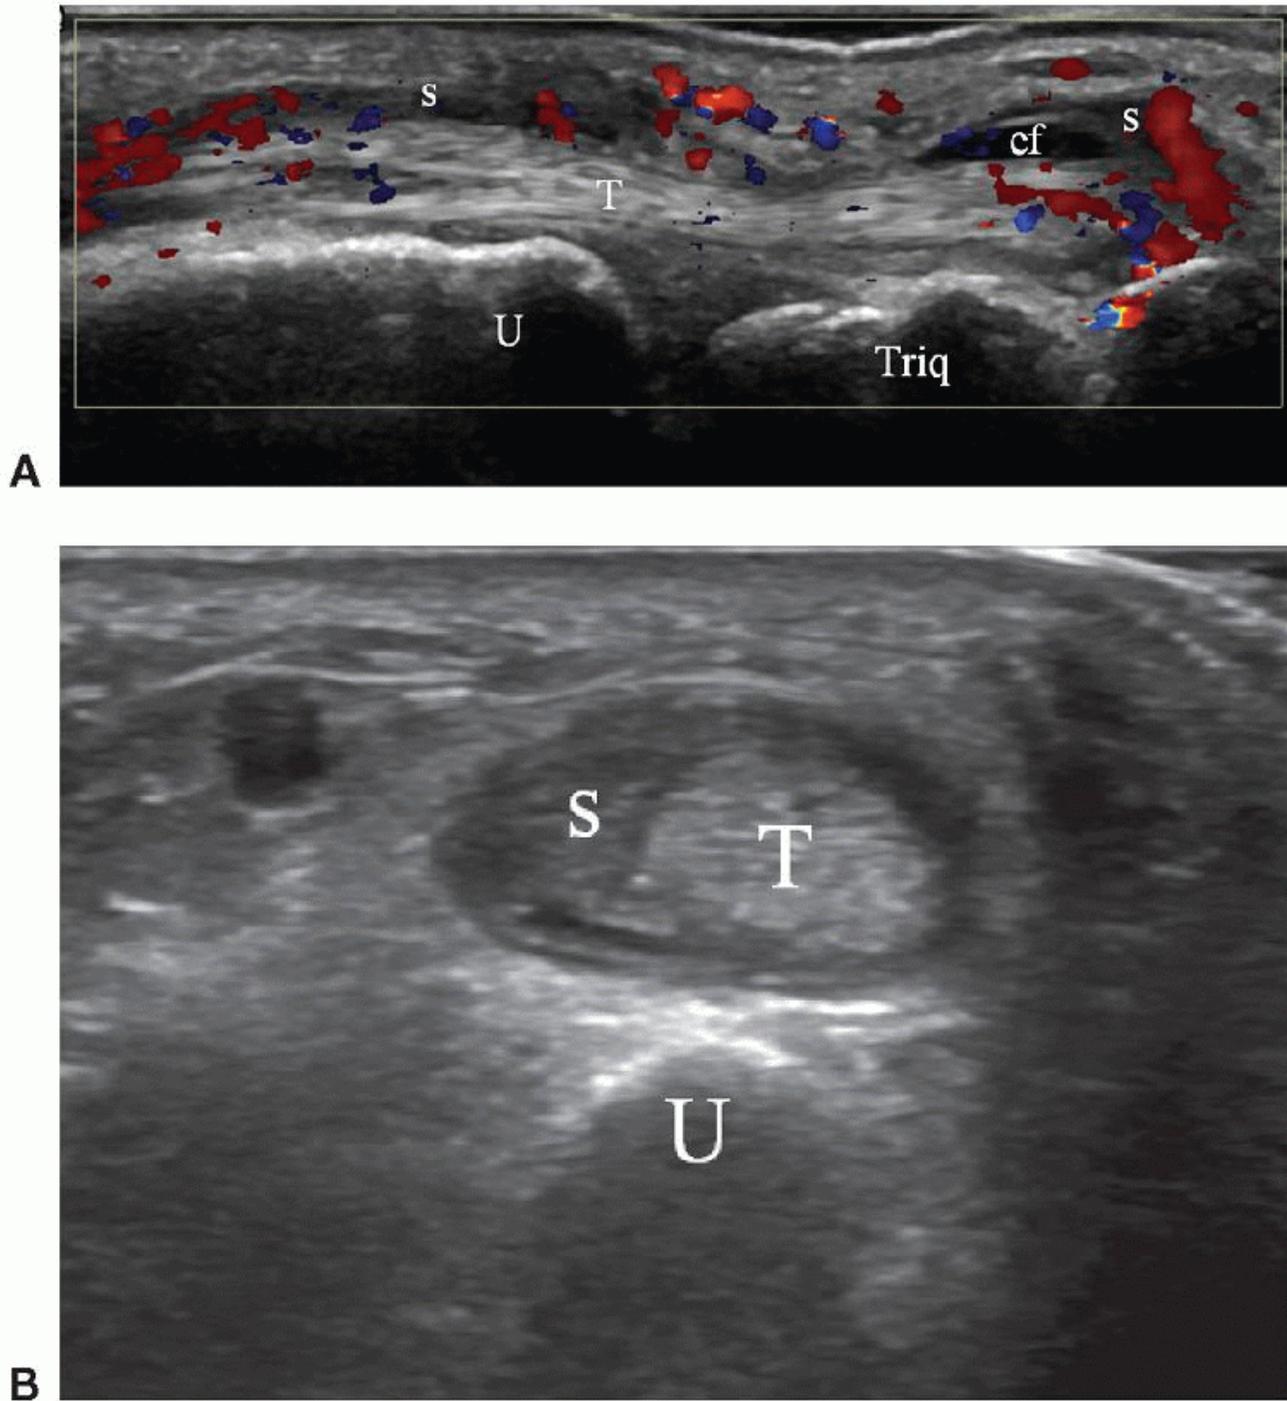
Longitudinal (A) and transverse (B) scans of the extensor carpi ulnaris tendon (T) at the wrist of a patient with RA and tenosynovitis. The tendon is slightly enlarged. Effusion (ef) and synovial thickening (S) in the tendon sheath. Color Doppler (A) shows tendon and synovial hyperemia. U, ulna; Triq, triquetrum.
